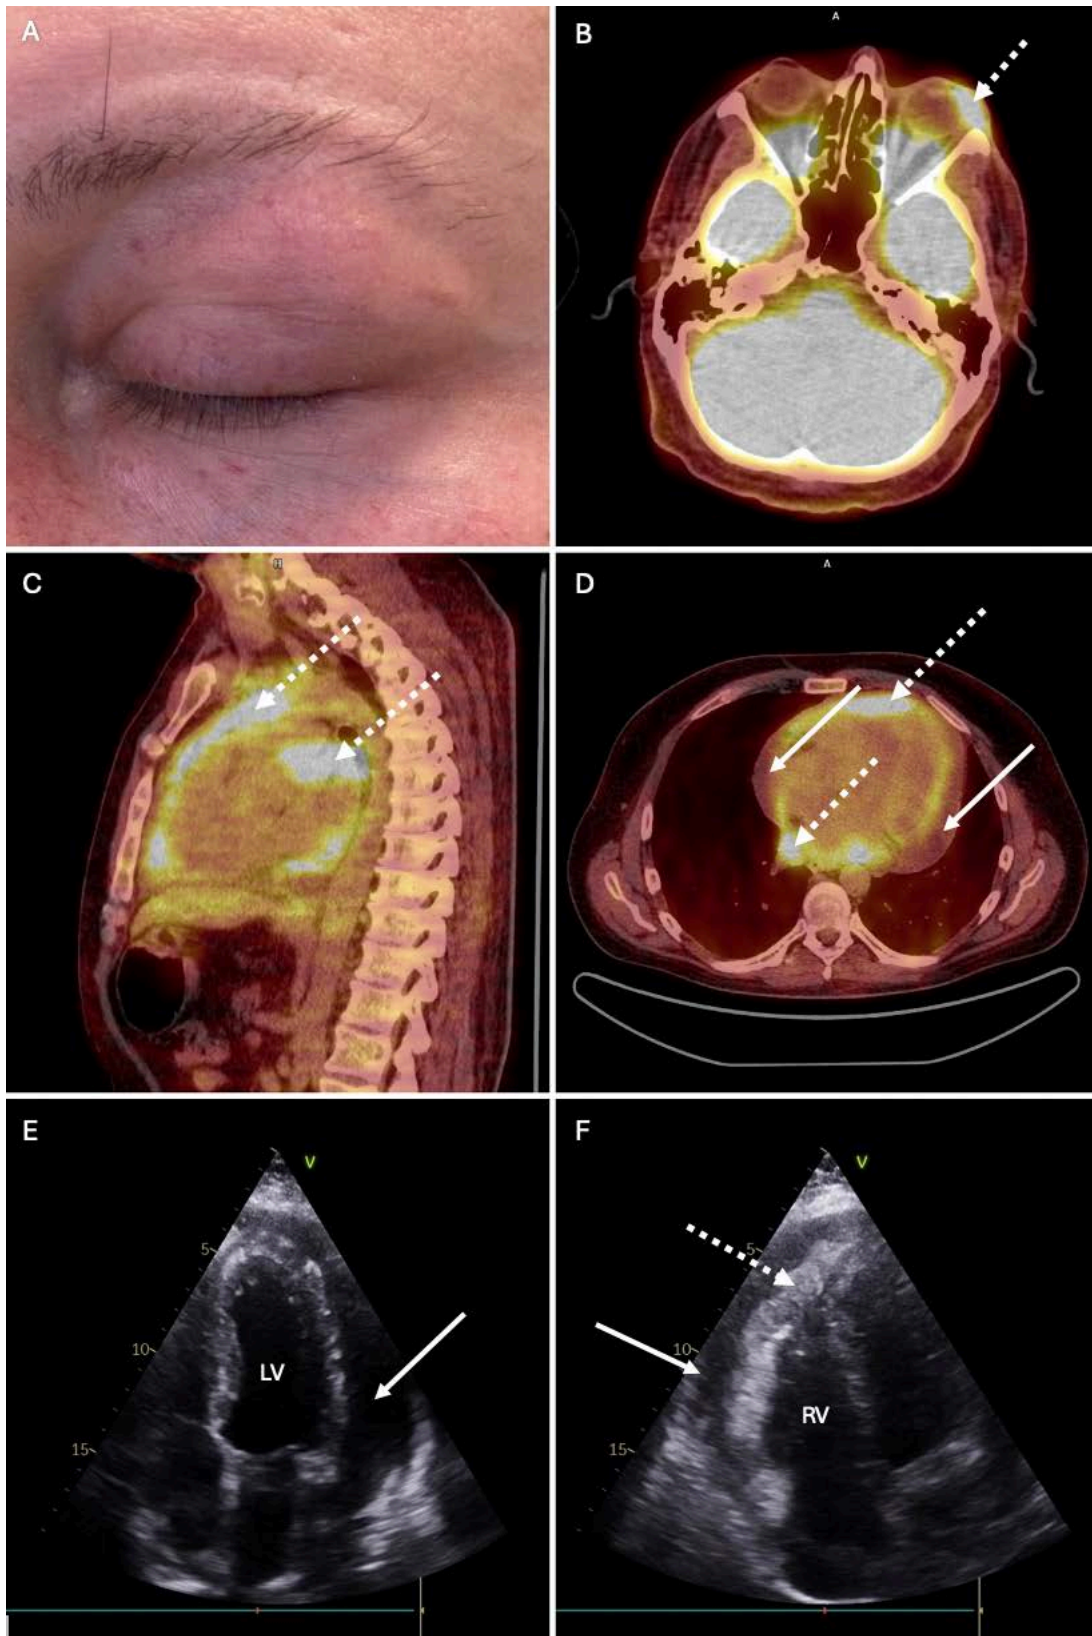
A. Left eyelid infiltration by T-ALL. B. PET/CT: active infiltrations within the eyelid and left lacrimal gland. C. D. PET/CT: active infiltrations within the pericardium associated with pericardial fluid. E. TTE: apical 4 chamber view. F. TTE: modified apical chamber view. Solid arrows point at pericardial fluid, the dotted arrows point at possible leukemic infiltrate
